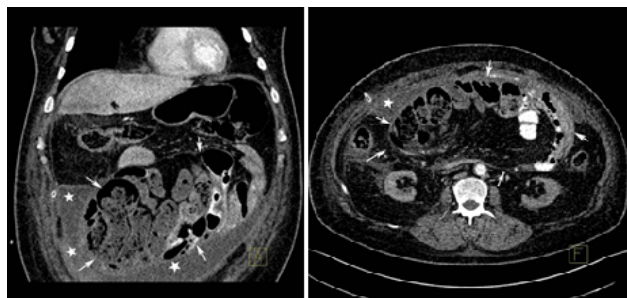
Abdominal coronal (a) and axial (b) maximum intensity projection (MIP) CT images show small intestinal loops encased by a thin fibrous membrane and concentrated to a zone inside a cocoon-like structure (arrows). A fluid collection surrounding the sac is also visible (asterisks). The colonic loops are seen outside the sac.
